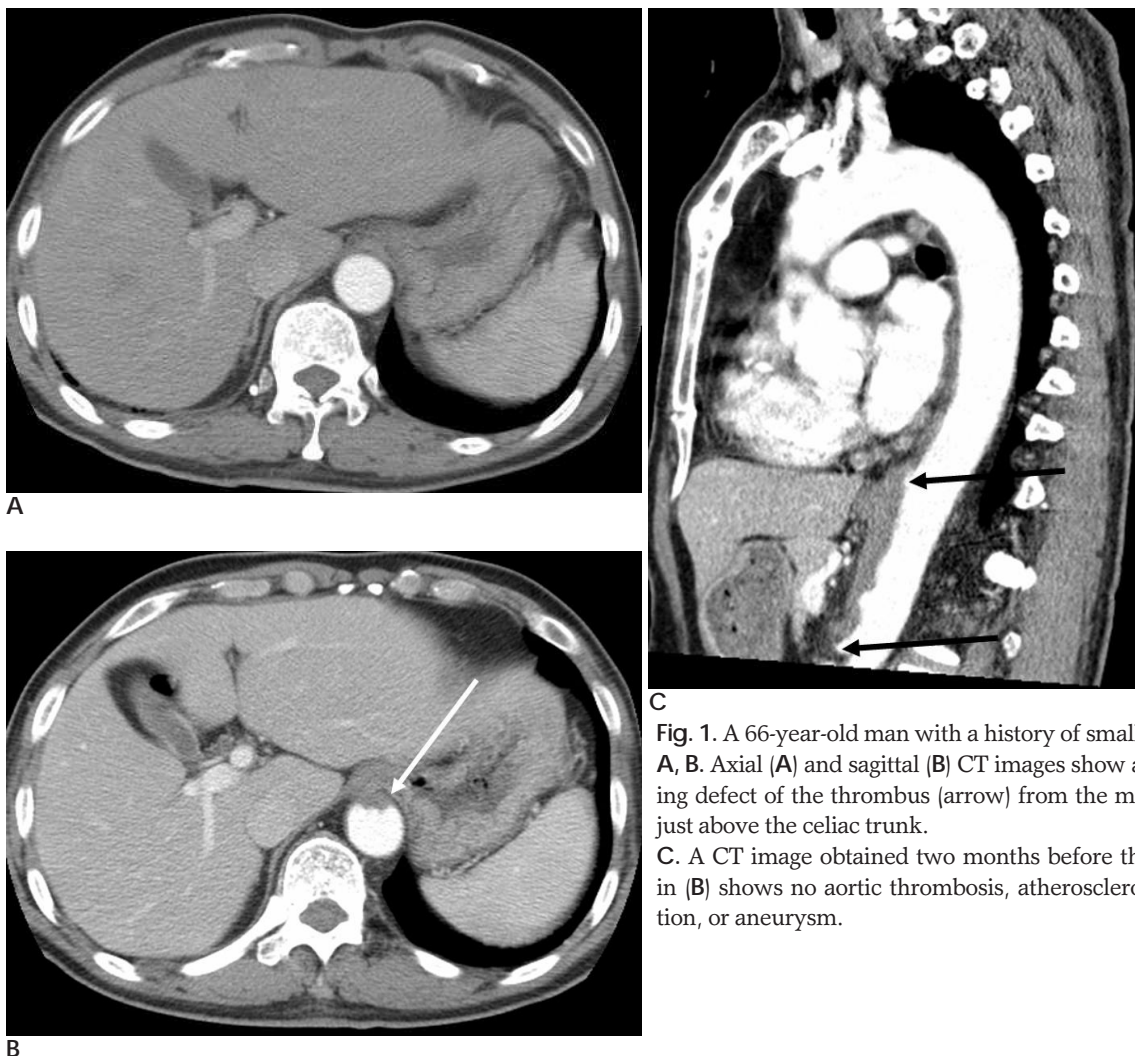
A 66-year-old man with a history of small cell lung cancer. A, B. Axial (A) and sagittal (B) CT images show an intraluminal-filling defect of the thrombus (arrow) from the mid thoracic aorta to just above the celiac trunk. C. A CT image obtained two months before the image presented in (B) shows no aortic thrombosis, atherosclerotic change, dissection, or aneurysm.
